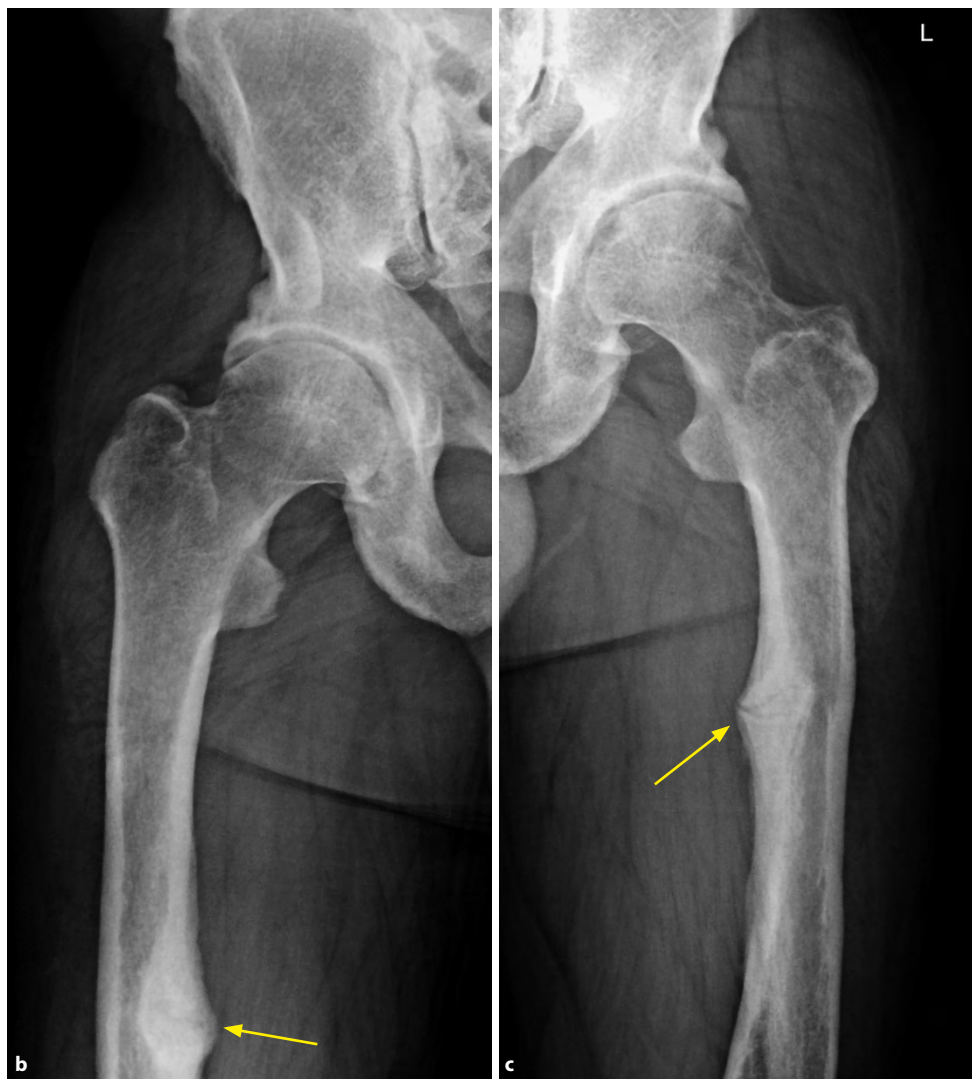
b, c. Radiographs verified remodelling of pseudo-fractures in the medial cortical bone of both femurs, see arrows. The arrow shows the pseudofracture in detail
